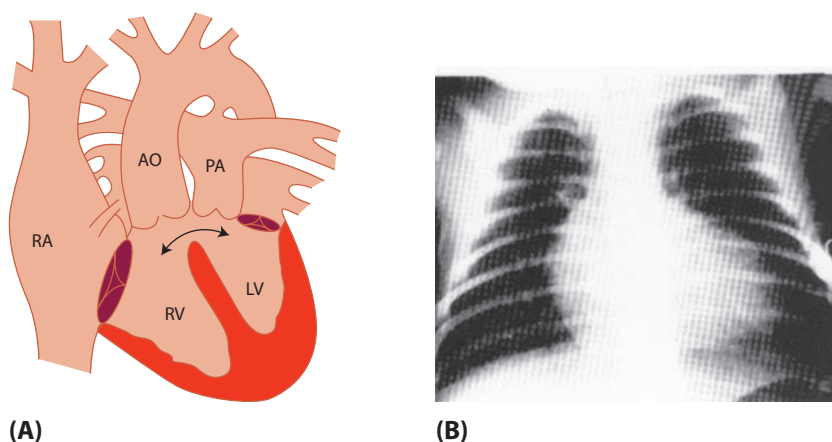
Transposition of the great vessels. "Egg on a string"—spinal column serving as the string and the globular presentation of the heart as the egg. (X-ray reproduced, with permission, from Moller JH, Neal WA. *Fetal, Neonatal, and Infant Cardiac Disease*, 2nd ed. Appleton & Lange, 1992: 532.)
